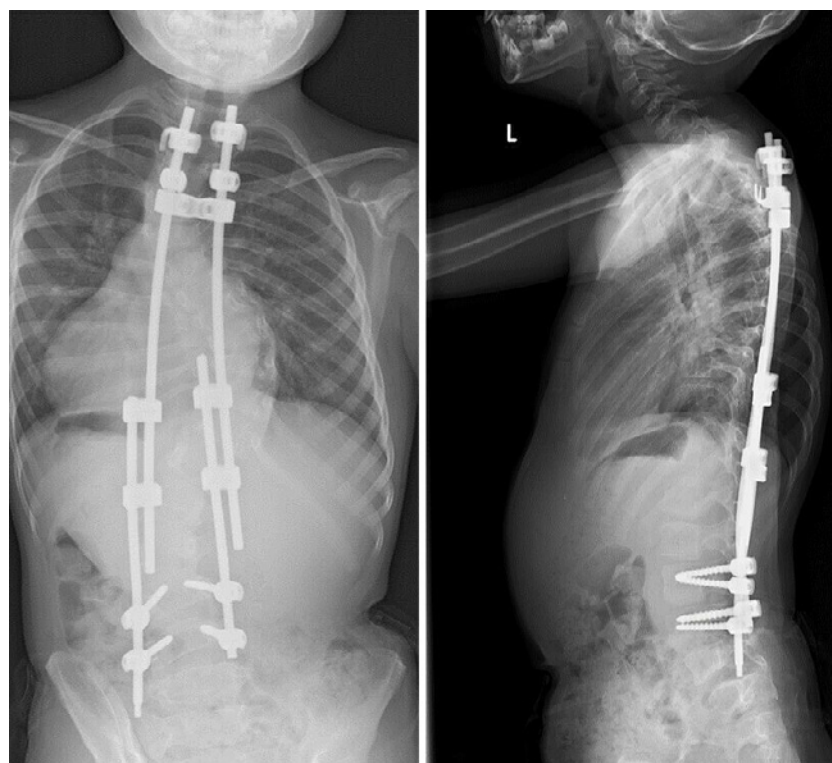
Radiographs after growing rod placement. At 4 years of age, growing rod surgery was initiated, placing the proximal anchor at T2 and T3 and distal anchor at L3 and L4, with the dual growing rods connected using side-to-side connectors.
